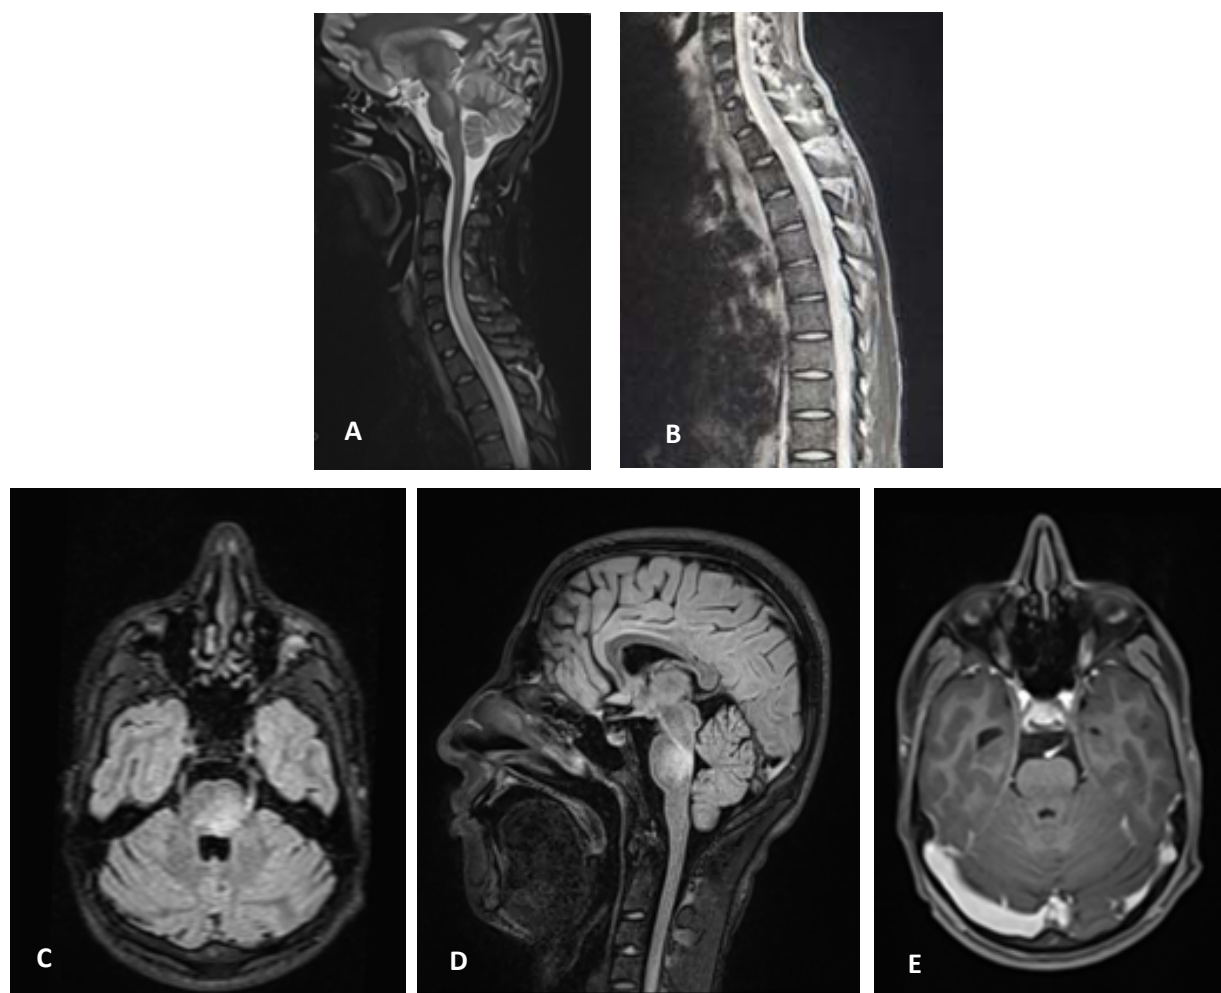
The MRI of the spine (A- sagittal STIR cervical , B-Sagittal T2W Thoracic, C and D axial and sagittal FLAIR brain and D-Axial brain post contrast) revealed a longitudinally extensive lesion involving the cervical and thoracic spinal cord, spanning from C3 to T10 with mild expansion of the cord. The lesion appeared hyperintense on T2-weighted images and hypointense on T1-weighted images. The MRI of Brain in this case also showed a lesion in the brainstem, predominantly involving the pons(Left>right), with areas of hyperintensity on T2-weighted images. No significant gadolinium enhancement was observed in the brainstem lesions.
